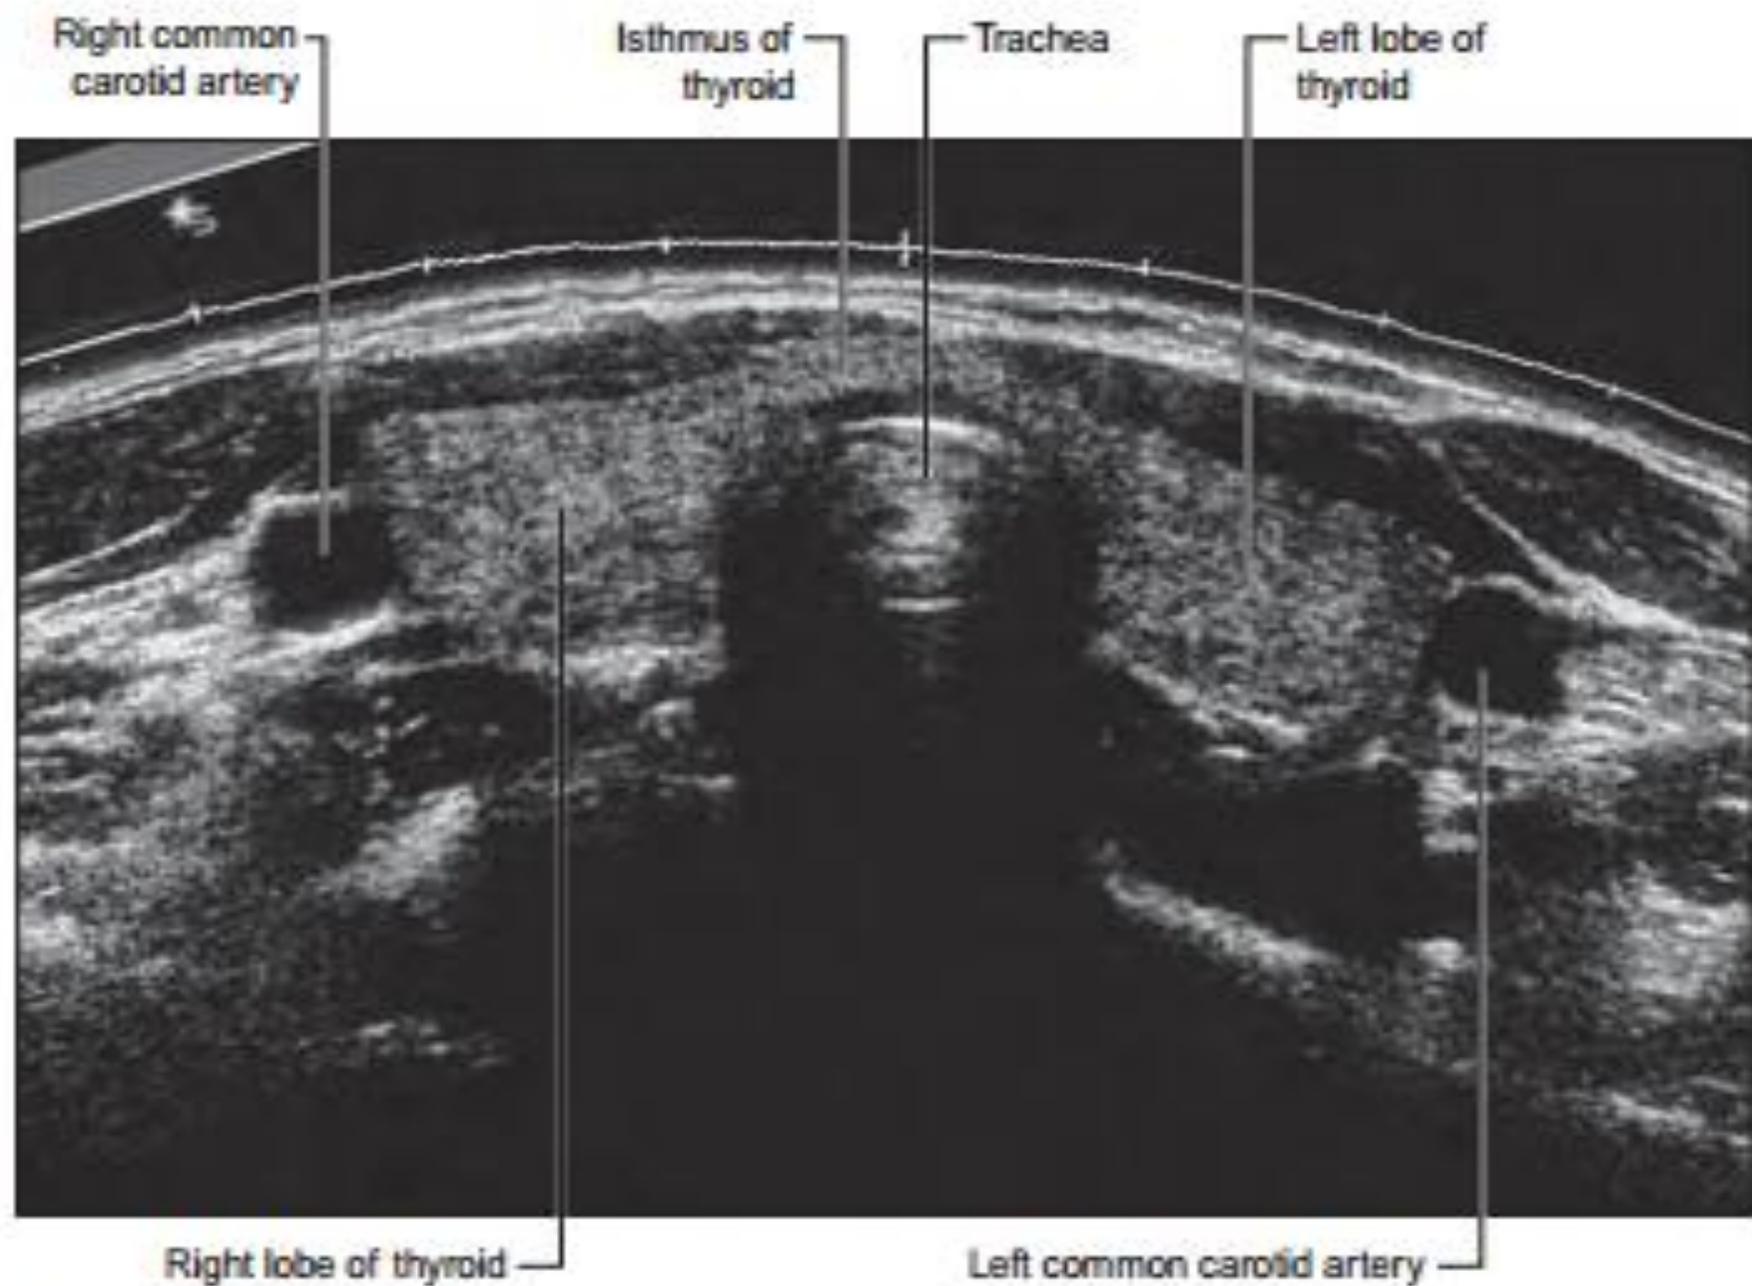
Thyroid sonogram.
